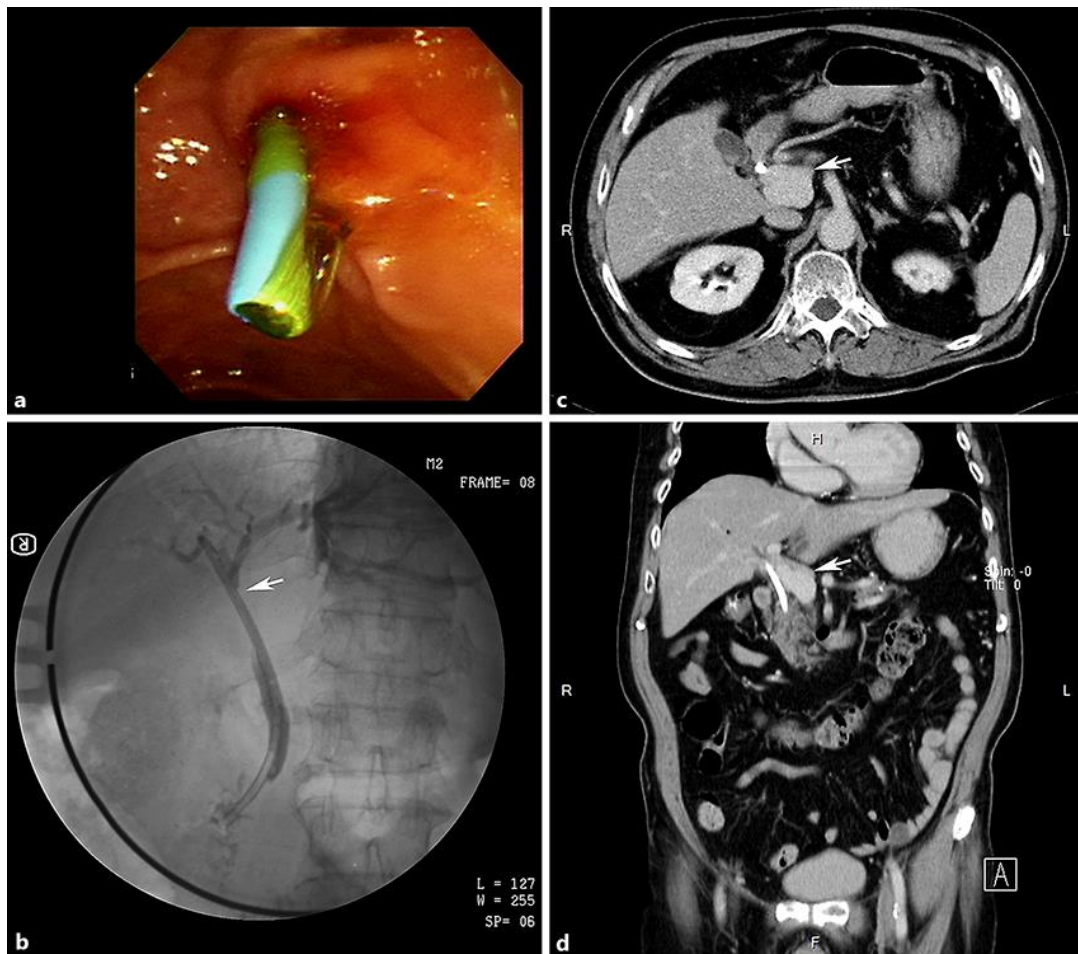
a Insertion of a biliary plastic stent into the common bile duct. b Fluoroscopy showing successful biliary tree drainage after stenting bypassing the stricture (arrow). c Contrast computed tomographic scan 6 h after endoscopic retrograde cholangiopancreatography revealing lobulated aneurysmal dilatation of the main portal vein with largest diameter measuring 3.2 cm (arrow). d Coronal section of enhanced CT scan demonstrating consistent finding of portal vein aneurysm (arrow).
